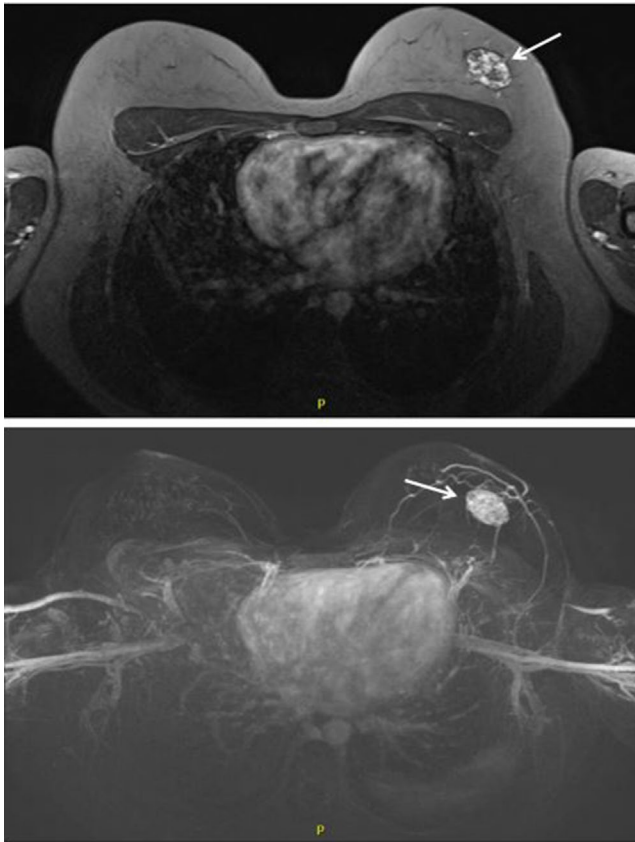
Magnetic resonance imaging (MRI) revealed a mass (arrow) consisting of calcifications located in the upper outer quadrant of the left breast, BI-RADS (Breast Imaging Reporting and Data System) 4
